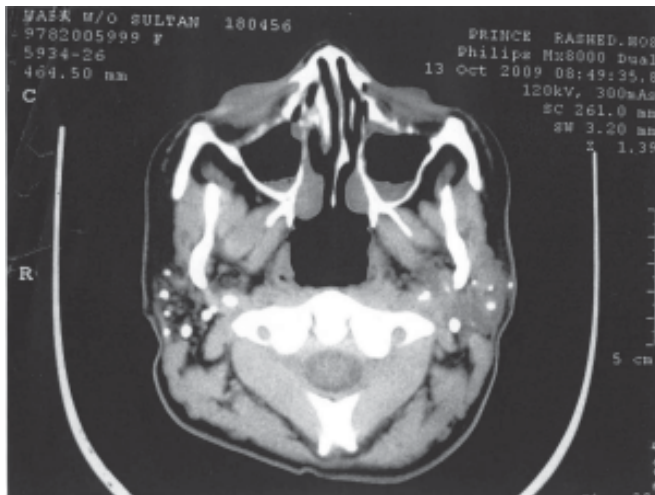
CT scan showing bilateral multiple parotid calculi of varying sizes. On the right side they are more.
